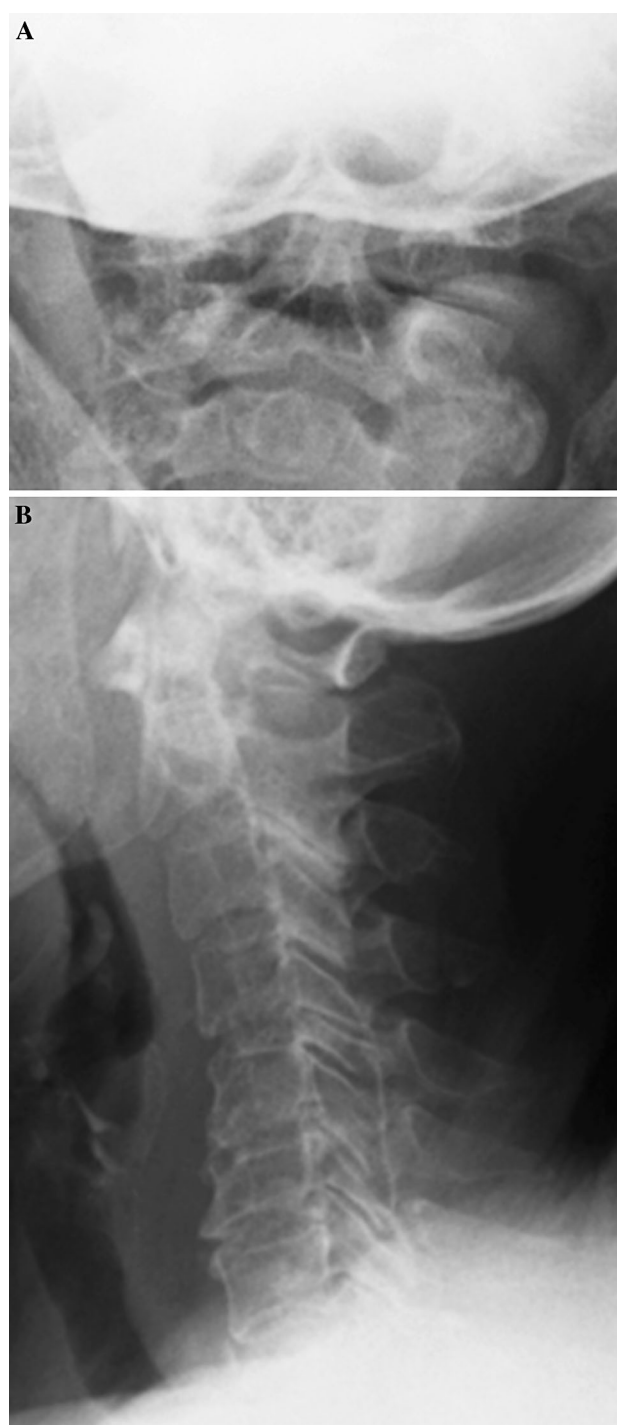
Plain lateral X-ray images at 5 months after injury showed slight kyphotic alignment and irregularity of the right lateral atlantoaxial joint and osteophyte formation of left C2–C3 facet joint. a Anterolateral view of the upper cervical spine. b Lateral view
